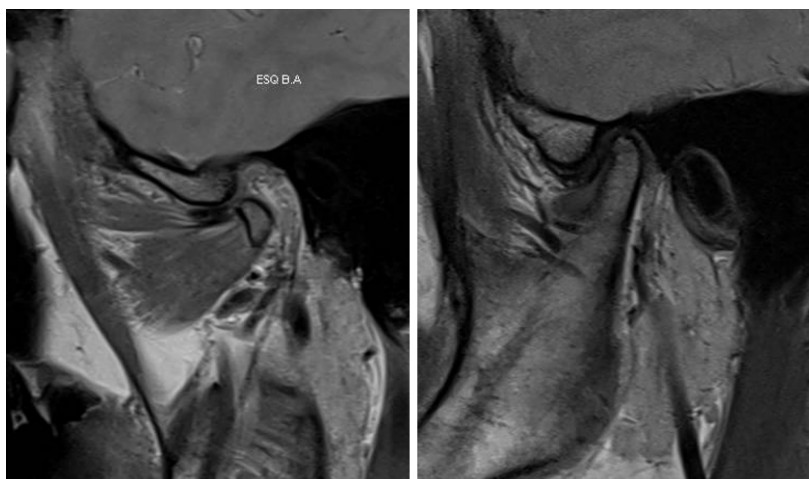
Temporomandibular joint MRI after occlusion bite.
